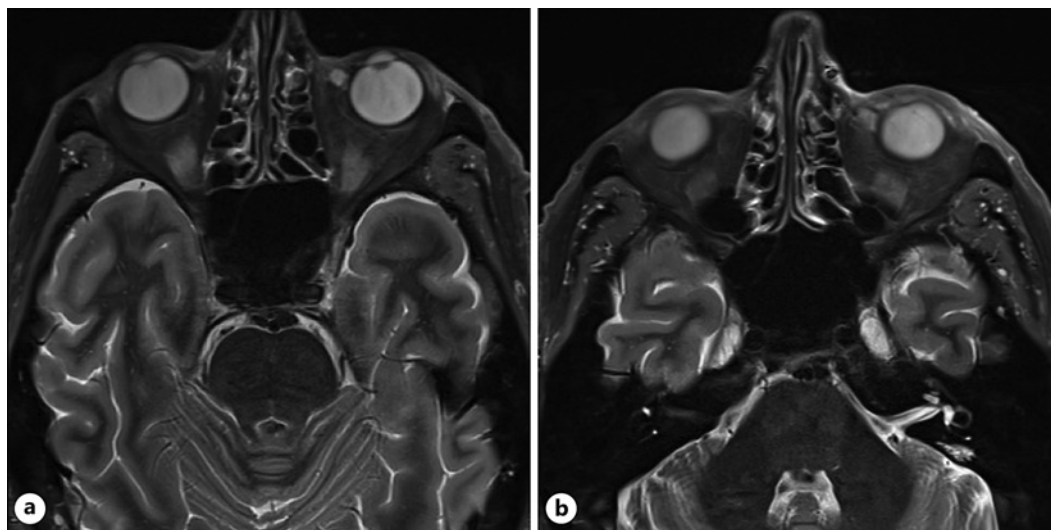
MRI of the orbits showing the tumor inferonasally of the left eye (T2 weighted, no contrast, slice 11/19) (a); and the grown lesion despite EBRT 6 months later (T2 weighted, no contrast, slice 12/19) (b).
